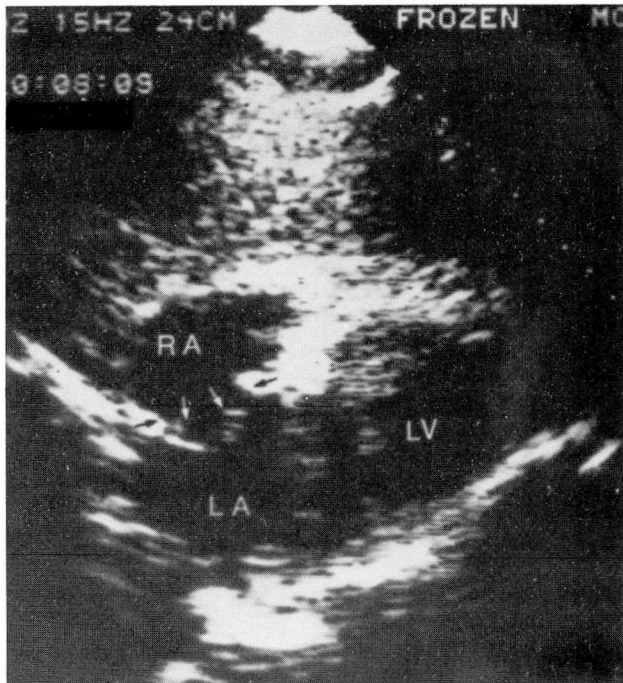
A. Apical two-chamber view in a patient with an atrial septal defect before arrival of contrast agent.
